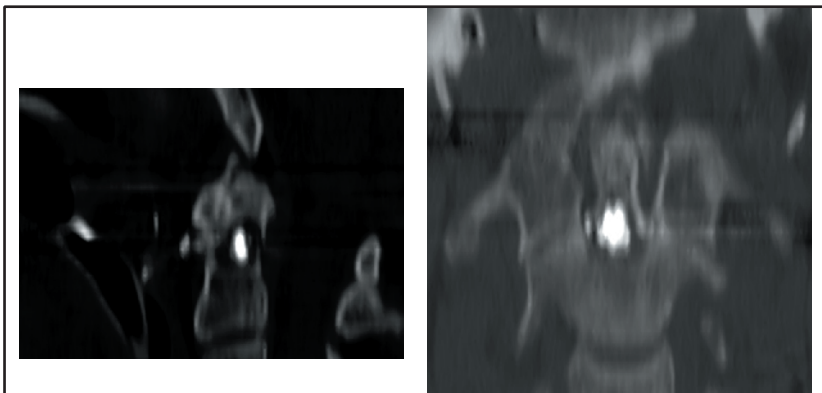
Post procedure CT (left, sagittal and right, coronal reformats) demonstrate optimal placement of PMMA into the dens of the C2 vertebral body.
